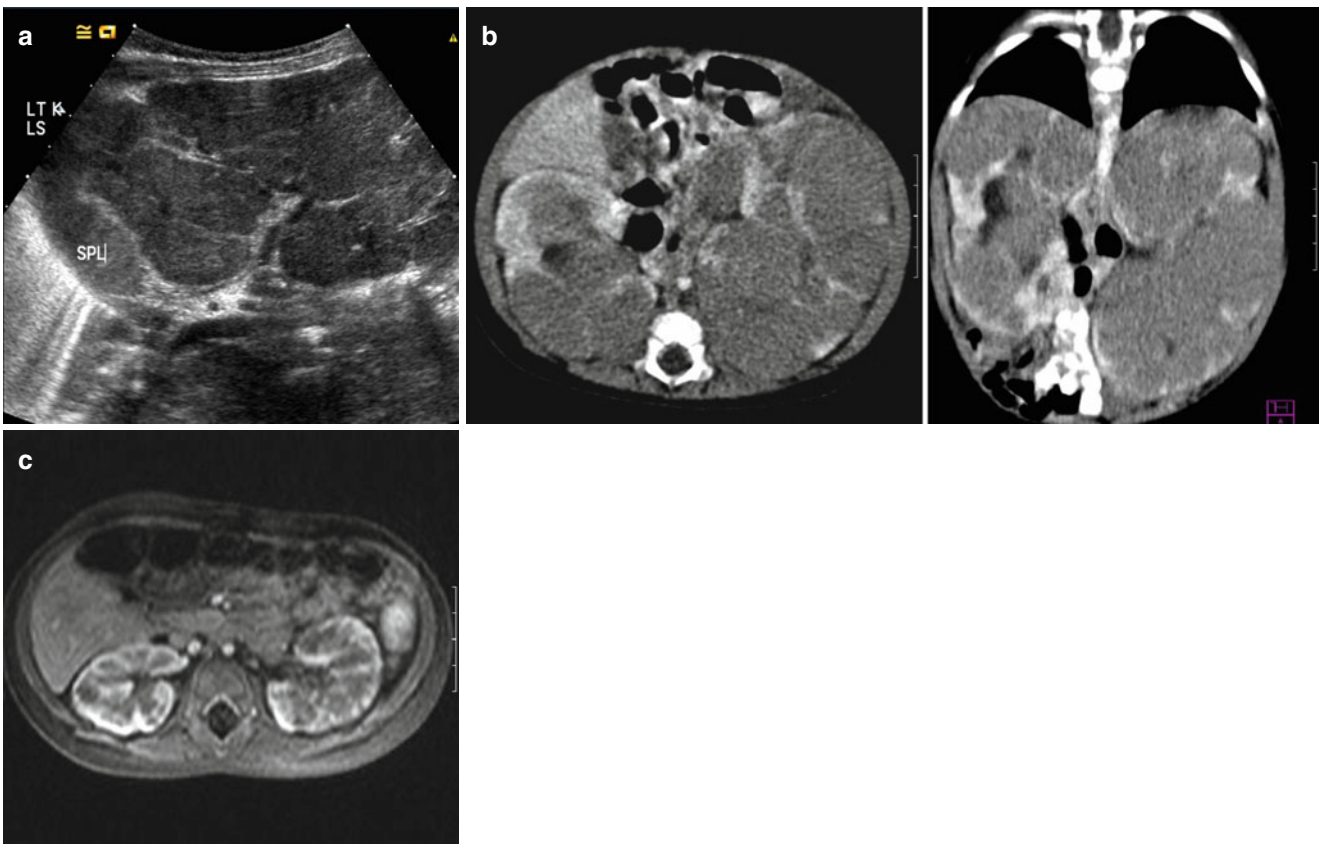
Nephroblastomatosis. (a) Ultrasound showing a diffusely enlarged and infiltrated left kidney, displacing the spleen superiorly. (b) Contrast-enhanced CT showing that both kidneys are diffusely affected
